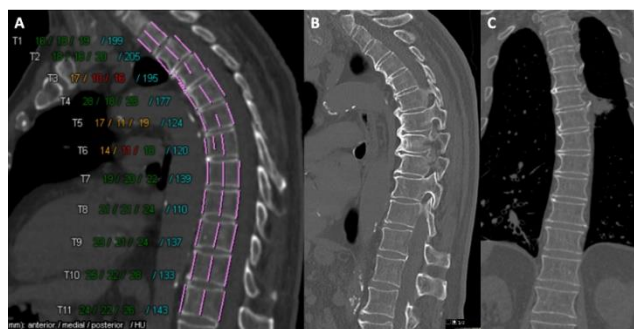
(A) Siemens® AI-RAD Companion Chest CT MSK results (MSK RANGE 4), and corresponding (B) sagittal and (C) coronal chest CT. Despite MSK RANGE 4, the expert panel concluded that there was no clinical relevance, corresponding only to degenerative changes in the spine. A possible explanation for the error in the segmentation of the algorithm could be due to mild scoliosis as shown in image (C).
